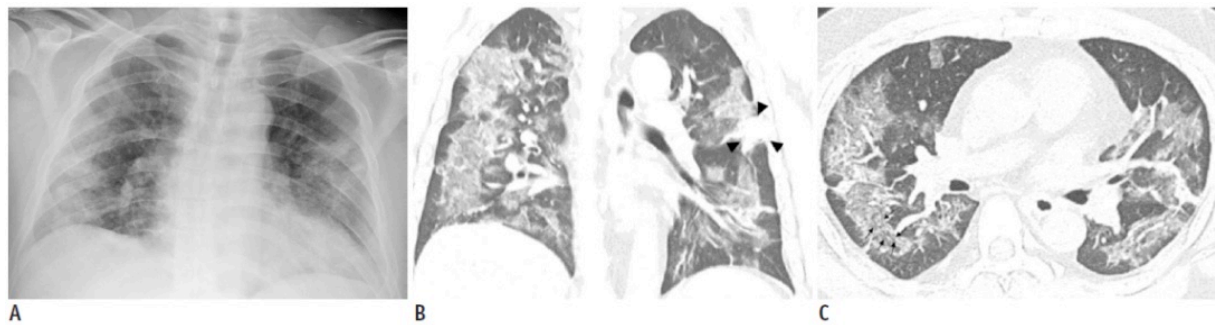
Representative CXR (A) and CT images (B, C) of COVID-19 pneumonia manifesting as confluent mixed ground-glass opacities and consolidation on CT. A. Anteroposterior chest radiograph shows multifocal patchy peripheral consolidations in bilateral lungs, except for left upper lung zone. B, C. Coronal and axial chest CT images show confluent mixed ground-glass opacities and consolidative lesions in peripheral bilateral lungs.
